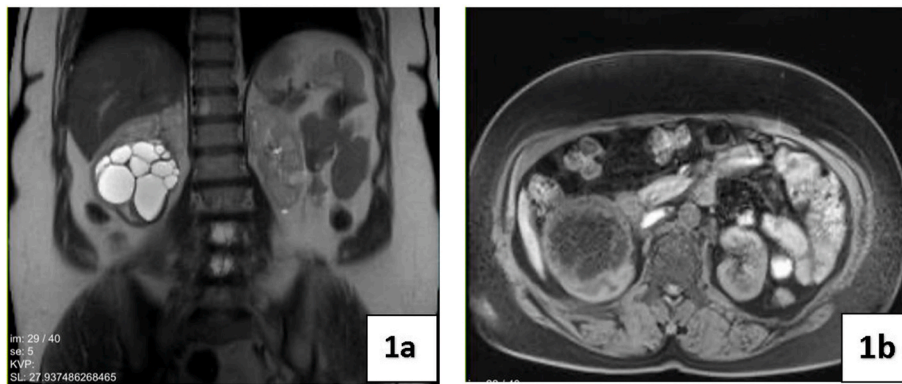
(a,b) CT scan showing multiloculated renal mass.
